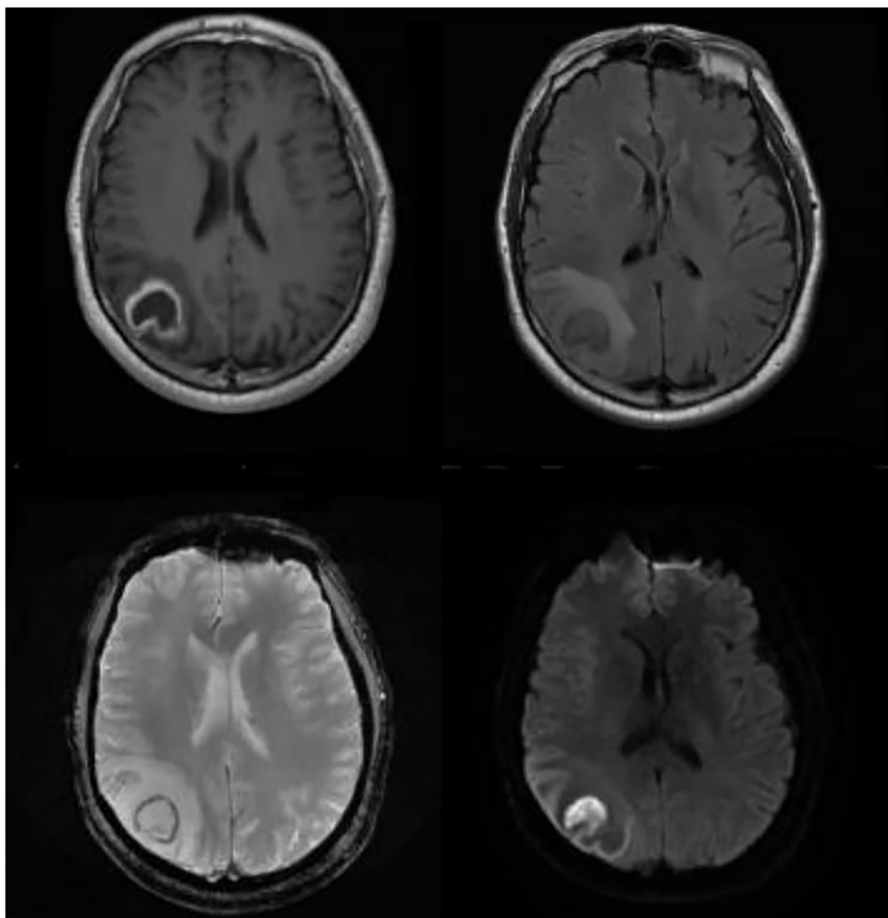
Upper left: T1 sequence with gadolinium showing irregular ring enhancement. Upper right: T2 flair sequence showing a mass lesion with prominent surrounding edema. Lower left: T2*sequence showing hypointensity in the wall of the lesion. Lower right: DWI showing restricted diffusion of the lesion.
